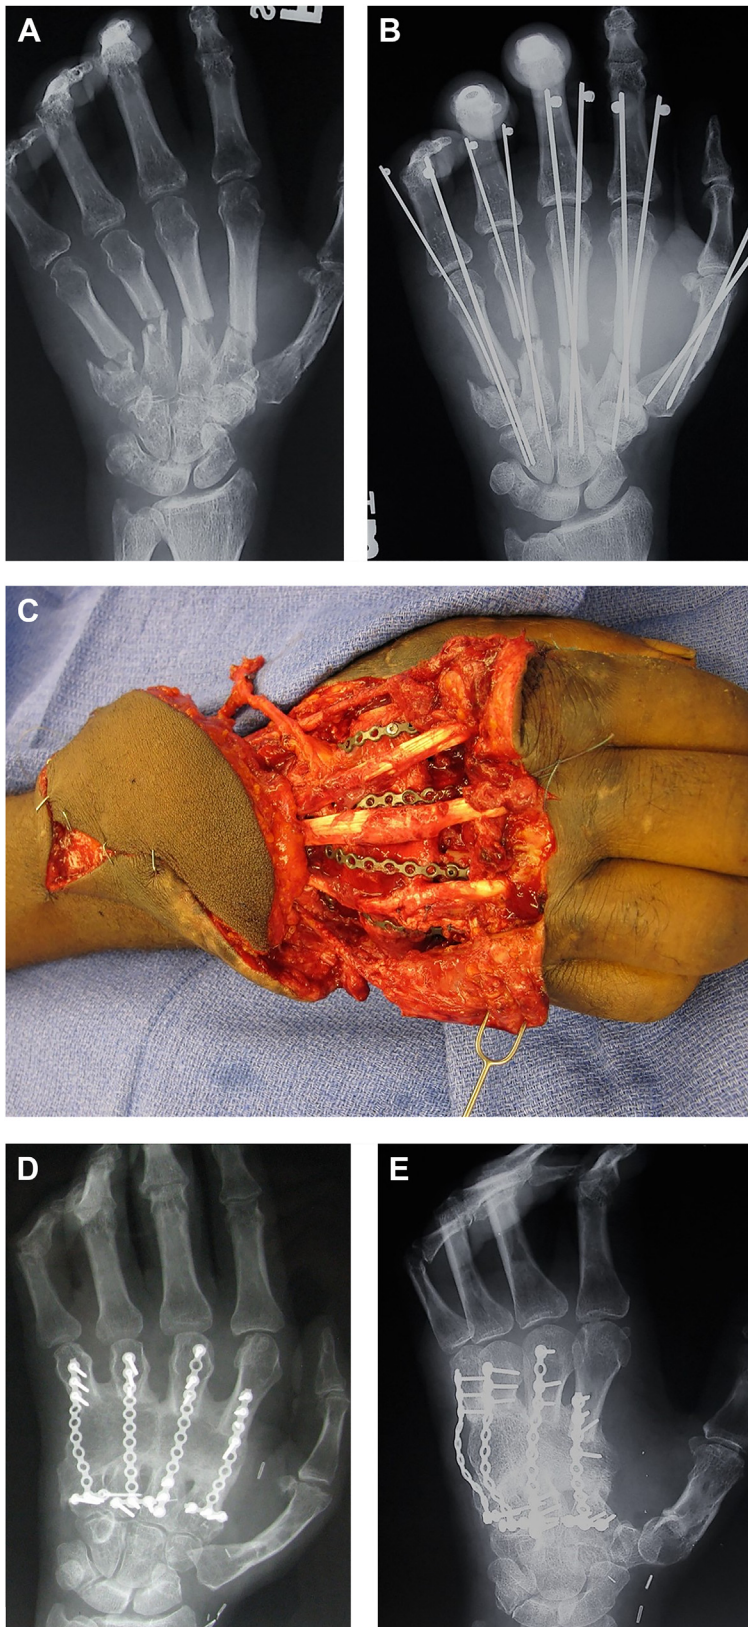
Example of multiple metacarpal nonunions treated with MFC flap. (A) AP radiograph of fixation of five metacarpal fracture sustained from an industrial crush injury. Pin fixation was utilized because of the tenuous appearance of the soft tissue on the dorsal hand. (B) Radiographs 4 months after surgery demonstrating the failure of healing of metacarpals 2-5. The poor quality of the dorsal hand skin was felt to be unlikely to heal if conventional plating and cancellous bone grafting was attempted. (C) Corticocancellous MFC with skin paddle inset into diaphyseal nonunions of metacarpals 2 to 5. Note that the midline of the bone flap was scored longitudinally and contoured so that the flap recreated the dorsal arch of the palm. (D) AP radiograph of hand showing generous healing at the eight osteosynthesis sites. (E) Oblique radiograph demonstrating the contoured arch of the plates to avoid contact on the dorsal vascularized periosteum.
